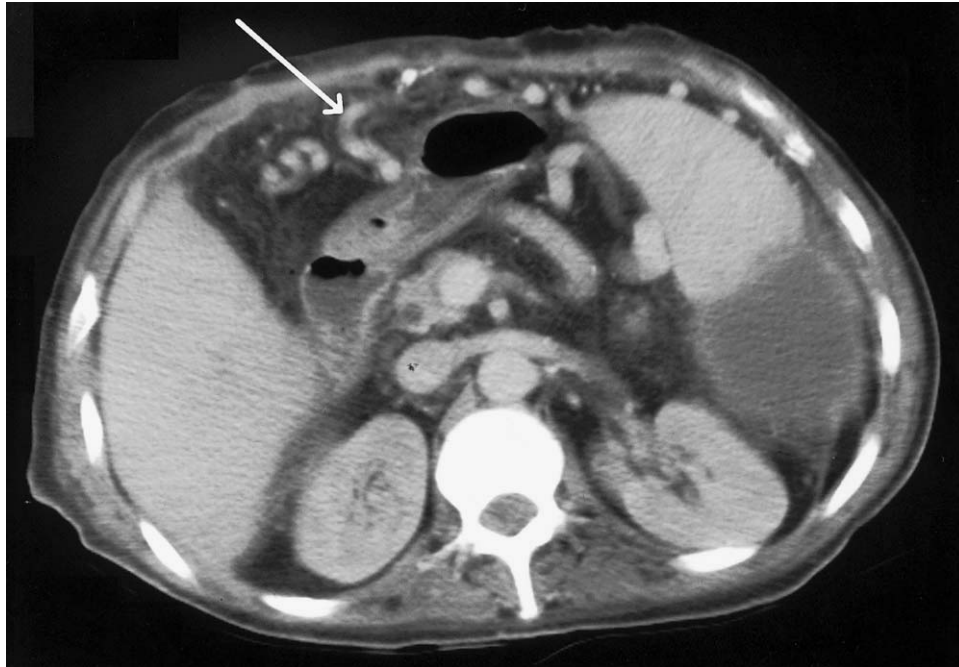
CT scan: cross section with arrow revealing anterior abdominal wall varix (see arrow).
